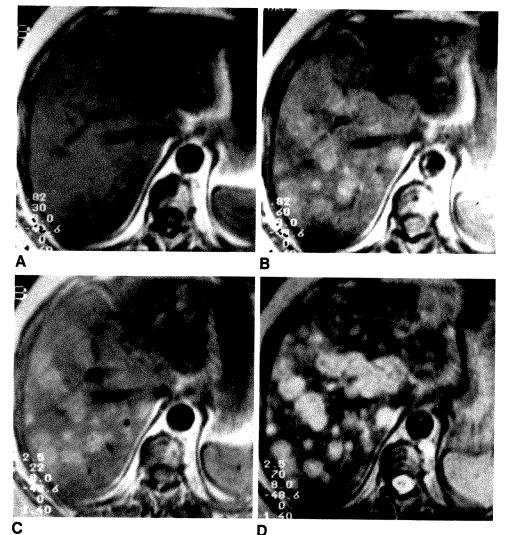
MR images of metastases from breast carcinoma before (A-D, this page) and 1 hr after (E-H, facing page) administration of ferrite show effect of ferrite on lesion-liver contrast for different pulse sequences. Lesion-liver contrast is increased on long TE images (B, D, F, and H). Though ferrite images yield somewhat higher contrast, lesion detection is not significantly improved compared with unenhanced T2-weighted images (D). Preand postcontrast series are not exactly comparable because patient was moved out of magnet for ferrite injection.
